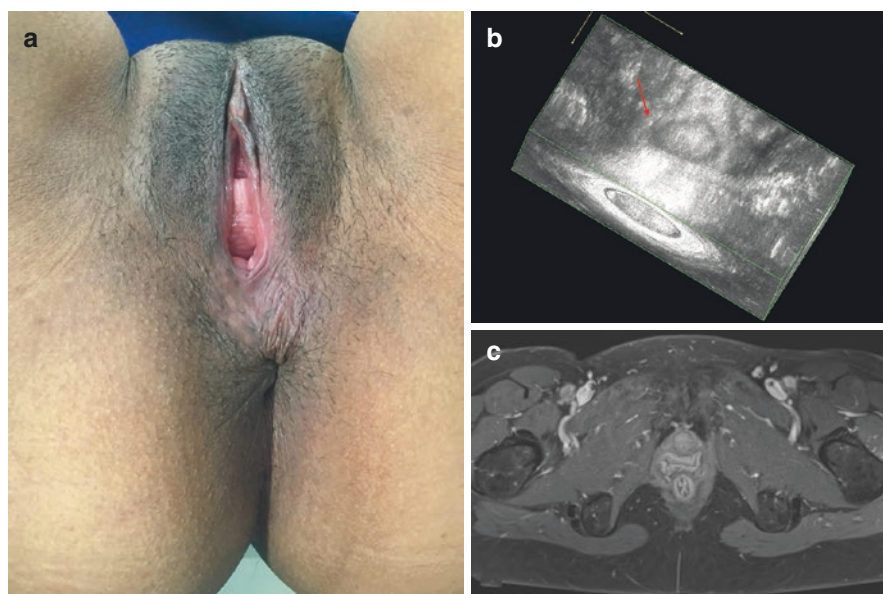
Clinical examination and ultrasonographic assessment of a ruptured puborectalis muscle. (a) Absence of midline symmetry. In this patient, the anus is retracted and shifted to the left side, whereas the puborectalis muscle rupture is located on the right side. (b) 3D endoanal ultrasound image, with coronal antero-posterior (A-P) view of the same patient, demonstrating puborectalis muscle defect (*thin white arrow*) on the right and a normal puborectalis muscle on the left (*bold white arrow*). (c) MRI image of right levator ani and puborectalis disruption
